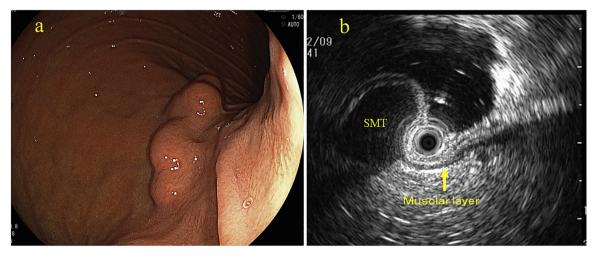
Upper gastrointestinal endoscopy showed a 30 mm submucosal polypoid lesion on the posterior wall of the proximal stomach (a). Endoscopic-ultrasound showed that the submucosal tumor was homogenous with an echogenicity similar to that of the normal muscularis (arrow) (b).
